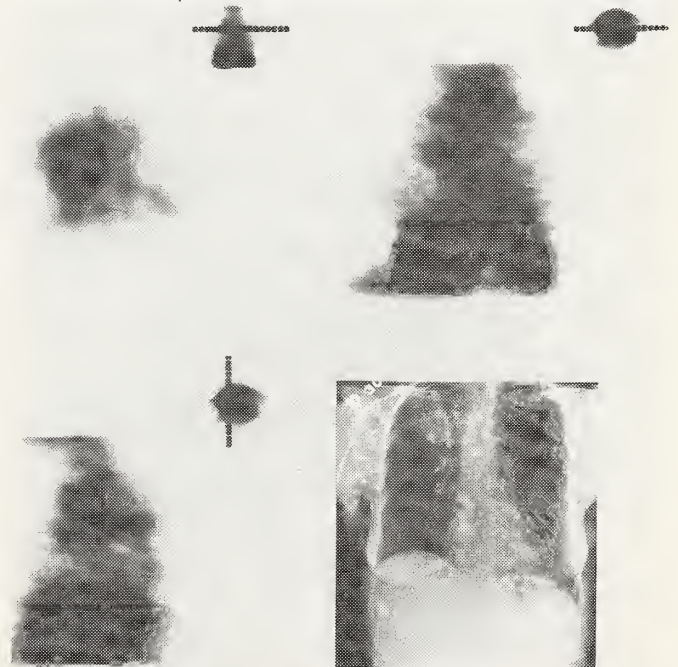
Unmodified thoracic SPECT images of a patient with a right lung lesion, taken 72 hours after administration of 120 mg of antibody. Clockwise from upper left: transverse reconstruction, coronal reconstruction, chest x ray, and sagittal reconstruction. Transverse slice is at the level of the primary lung lesion. Reference planes for each of the slices are on the upper right. (Figure courtesy of J Natl Cancer Inst) (39).
